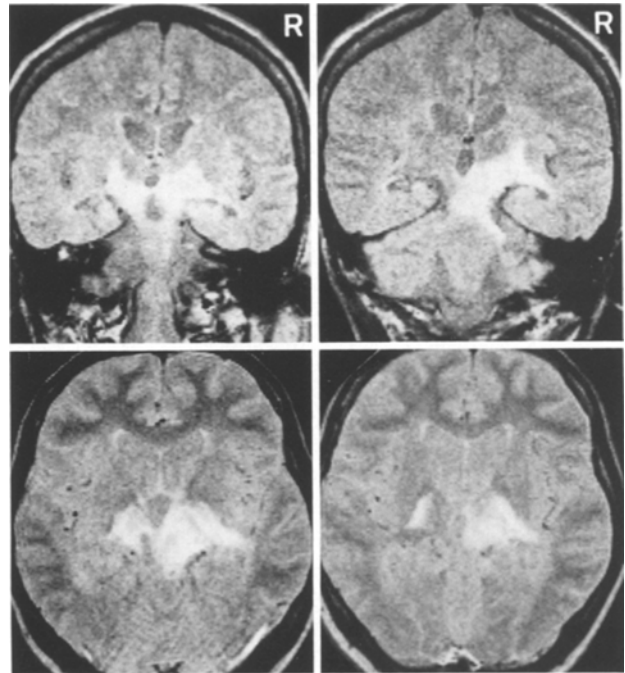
T2-weighted MRI of case 2, 5 days after the onset of clinical symptoms. An extensive high signal area is seen in the brain stem, bilaterally involving upper pons, cerebral peduncles, thalamus and posterior limbs of internal capsule with right sided predominancy
